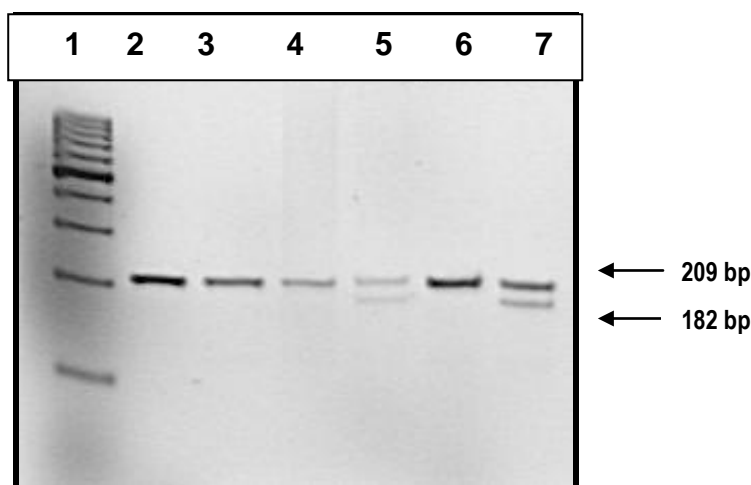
Mutagenic primers amplified a 209 bp fragment for a *Tsp509I* restriction enzyme digest that enabled identification of SNP c.589-5 C>T in the amplicon containing exon 9 on a 3% (w/v) agarose gel. Lane 1 = 100 bp molecular weight marker (O'GenerulerTM, Fermentas); lane 2 = undigested fragment (209 bp), lanes 3, 4, 6 = CC, lanes 5, 7 = CT.
